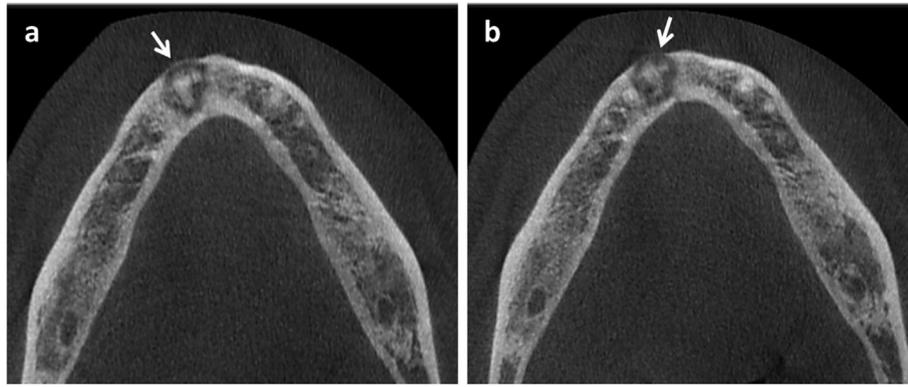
Two different axial cone beam computed tomography slices of the same periapical cemento-osseous dysplasia case showing the effects on cortical bone: a. thinning + expansion and b. perforation (white arrows).
